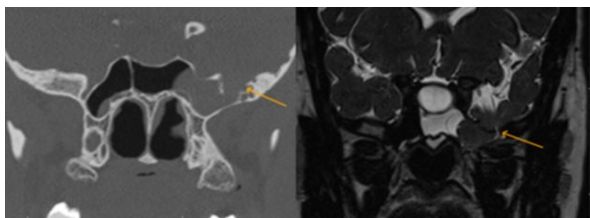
HRCT demonstrates bony defect in the sphenoid roof. MRI demonstrates herniation of the left inferior temporal gyrus into the lateral recess. Pooled CSF is also noted medially in the left sphenoid sinus. Also there is a large empty sella suggesting the possibility of idiopathic intracranial hypertension.
